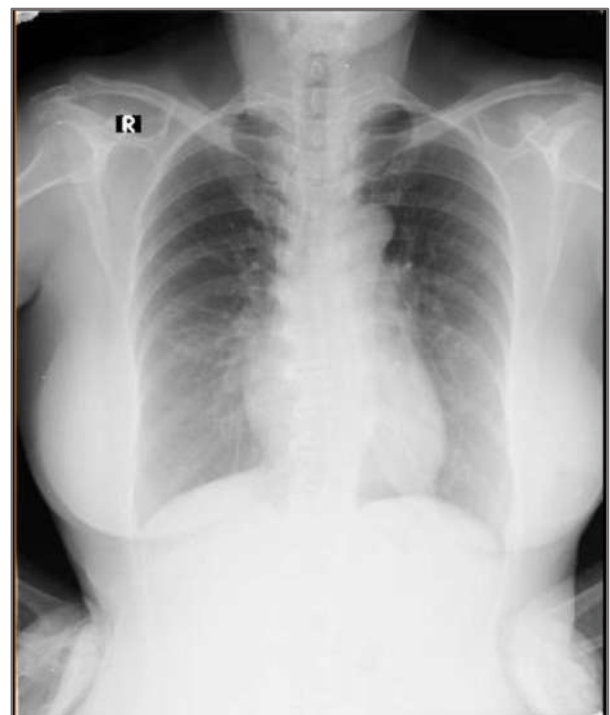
Preoperative chest x-ray of patient
